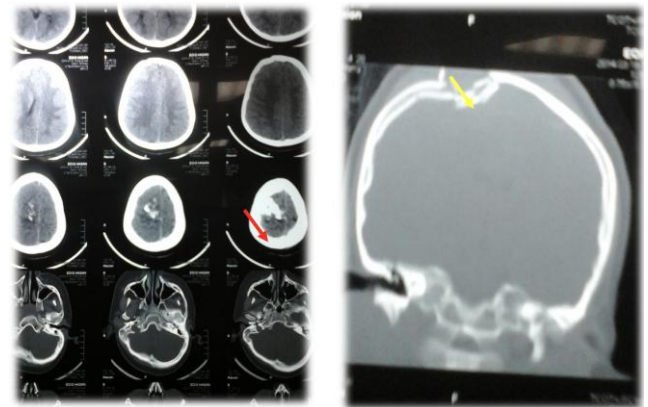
Pre-operative CT of Case 3
